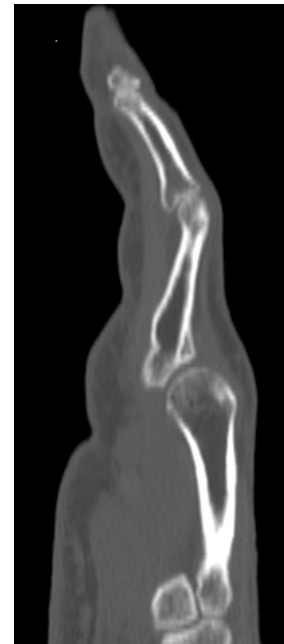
Computed tomography image of the malunion with dorsal angular deformity.
